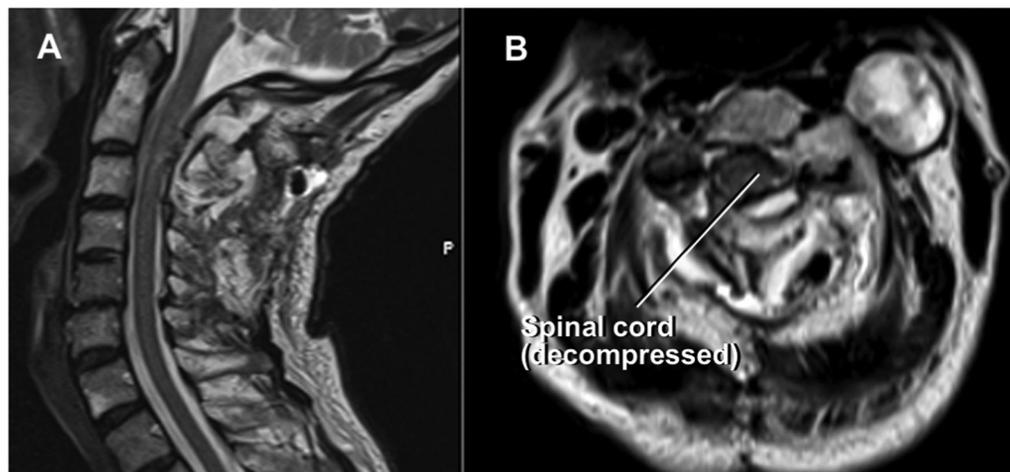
Postoperative magnetic resonance images (MRIs). T2-weighted MRI in sagittal (A) and axial planes (B) and at the level of C3 corpus. The spinal cord is seen to be decompressed.
